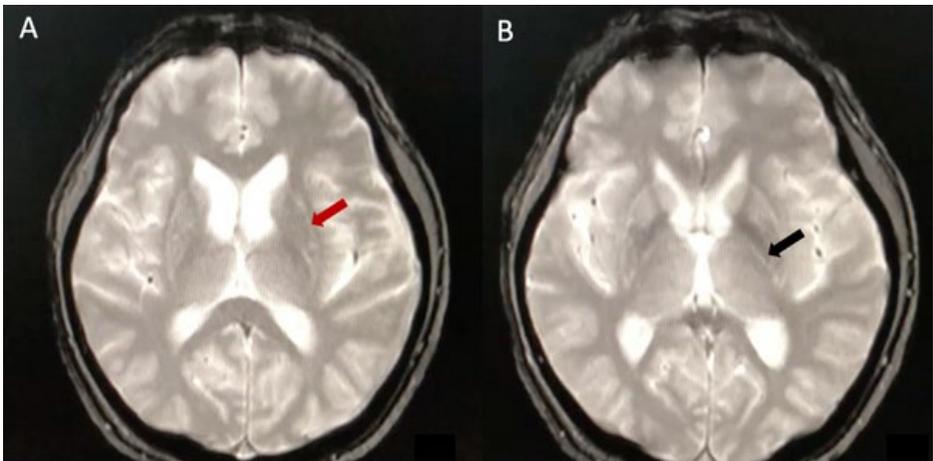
Neuroimaging findings. Cranial MRI (Gradient echo sequence) showed hyperintensities in the putaminal rim (A) and pallidal rim (B).
